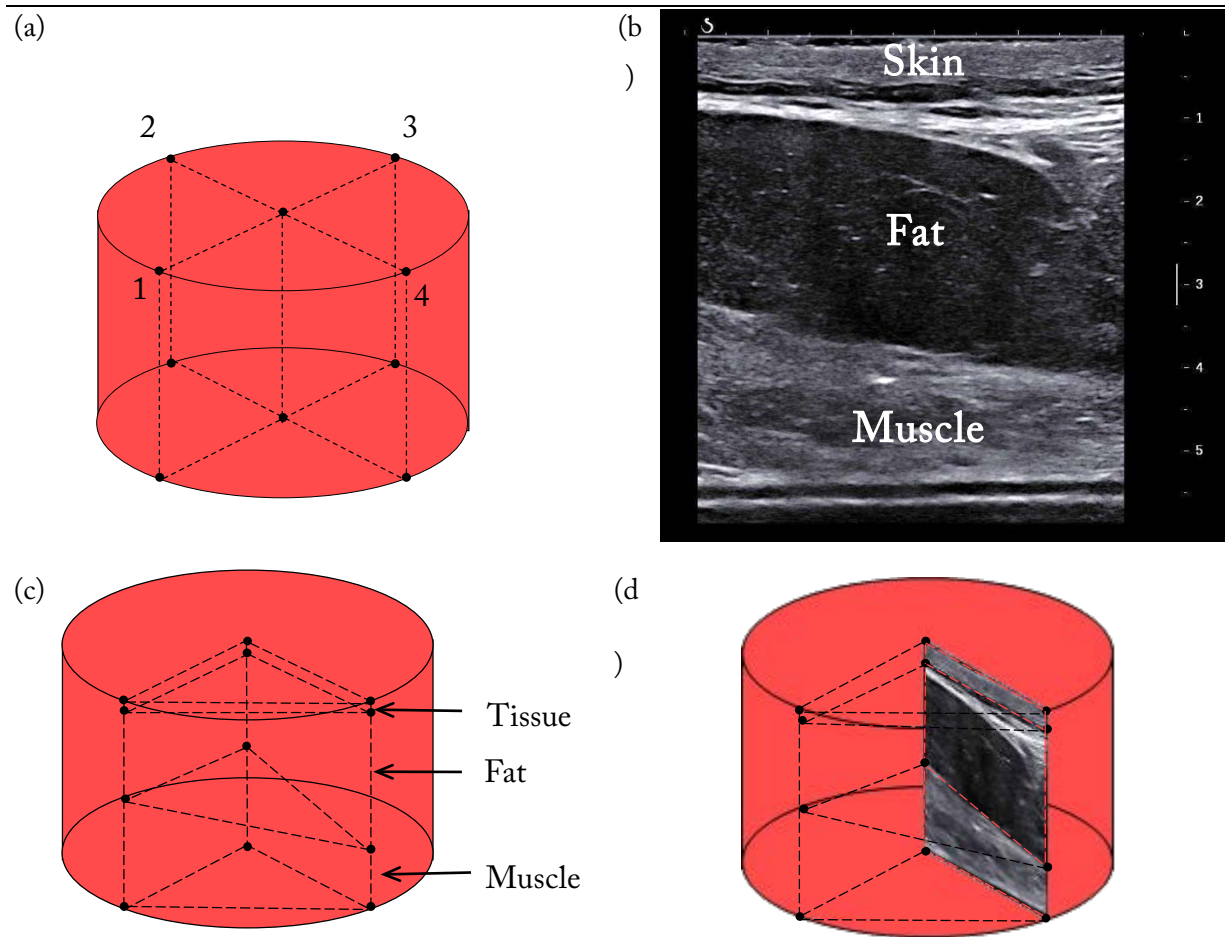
Four planes (a) were imaged using ultrasound (b) to obtain skin, fat, and muscle thicknesses of each sample. Ultrasound planes were used to approximate volume percentages by using right triangular prisms (c). Notice the triangular prisms capturing the gross uneven fat and muscle layers found in the ultrasound image (d).
